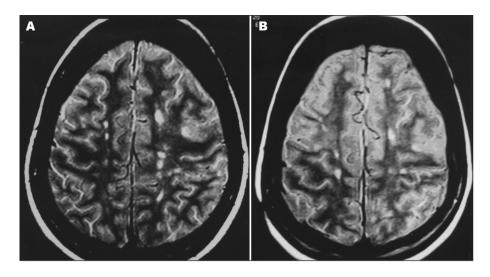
Axial T2 weighted MRI. [A] Multiple plaques in the white matter A (1996). [B] Slight improvement of high signals in periventricular white matter (2005).
